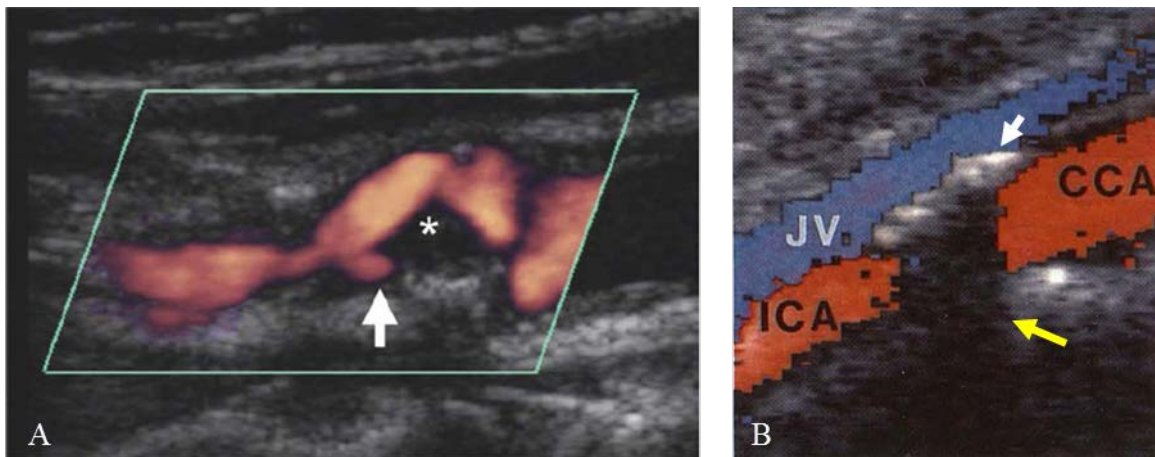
(A) Doppler ultrasound shows an internal carotid artery plaque ulceration (white arrow). The figure is adapted with permission [1]. (B) the calcification in the anterior vessel wall (white arrow) shadows the colour Doppler signal and opposite wall structures (yellow arrow). The figure is adapted with permission [1].
